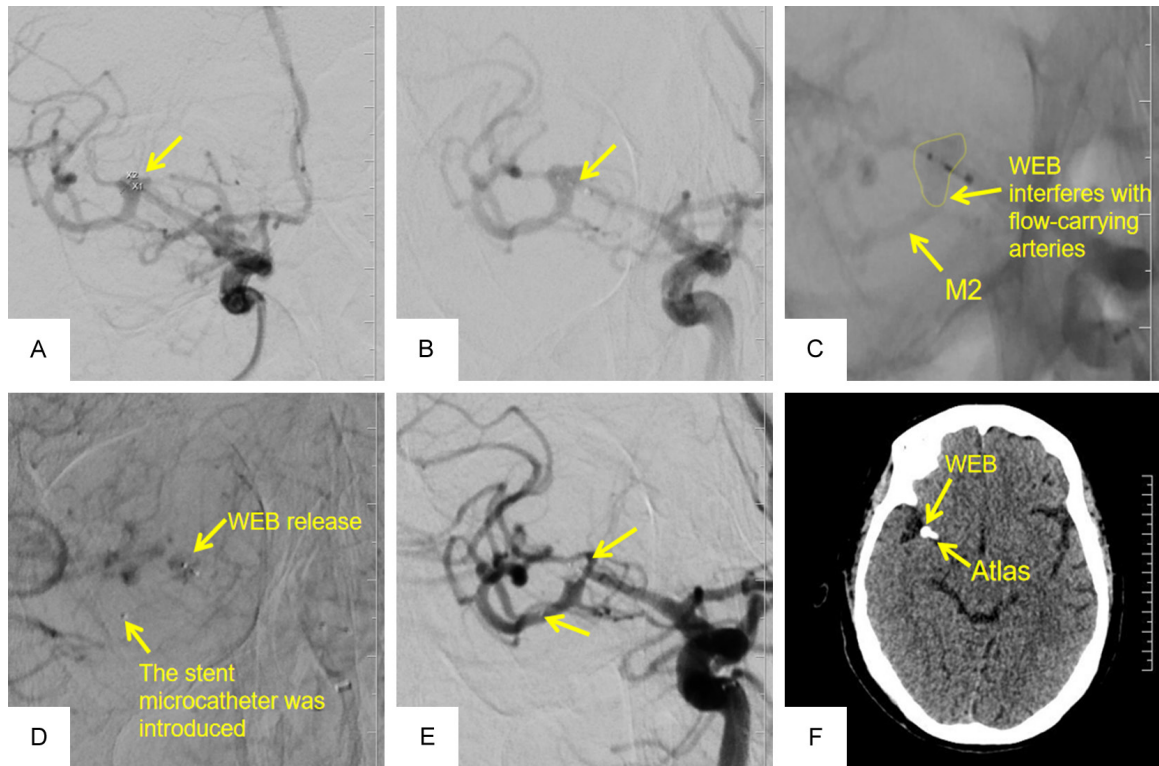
Note: (A) Preoperative angiography showed an aneurysm at the right MCA M1 bifurcation; (B) WEB was successfully released into the aneurysm at the right middle cerebral artery M1 bifurcation; (C) The WEB system partially interfered with the parent artery; (D) The stent microcatheter was introduced and the WEB was released; (E) After the WEB and stent were placed, the aneurysm was embolized satisfactorily and the parent artery was unobstructed; (F) Postoperative follow-up CT: WEB and Atlas stent were stable, the aneurysm was completely embolized, and the parent artery was unobstructed.
